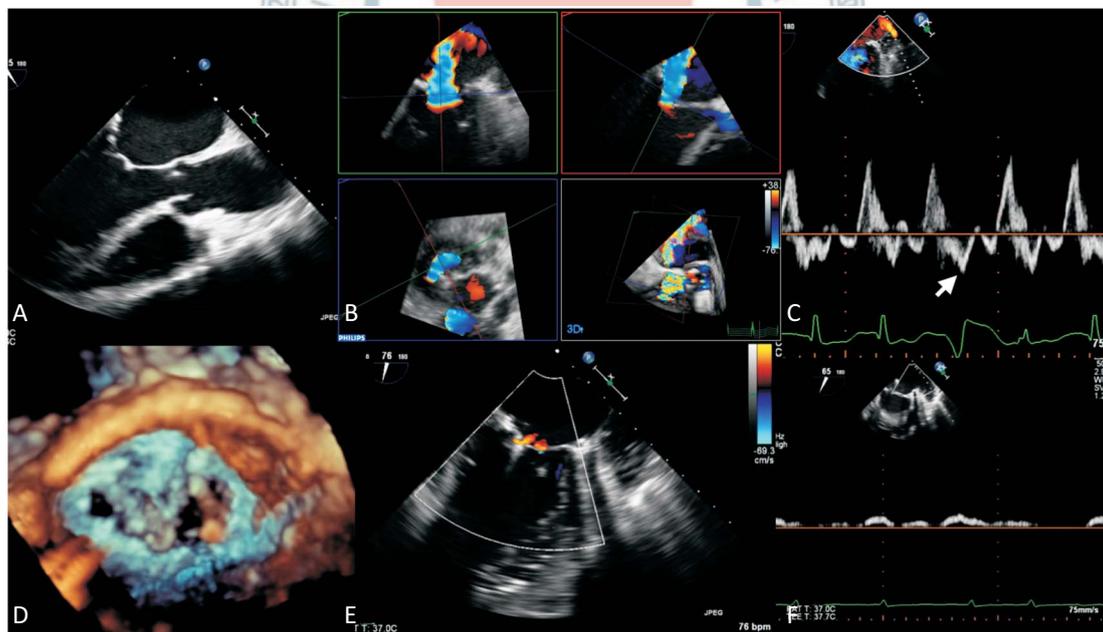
(A) TEE LVOT view demonstrated tethering of both mitral leaflets with a small gap between anterior and posterior leaflet. (B) QLAB 10.0 (Philips Healthcare) 3D color Doppler reconstruction demonstrated the significant MR jets coming from central A2-P2 site. (C) White arrow indicated the reversed systolic flow in left upper pulmonary vein. (D) 3D enface view from LV. It elucidated that the clip is located at central A2-P2 location. (E) TEE bi-commissure view with color Doppler demonstrated only mild MR left after a single clip. (F) TEE demonstrated disappearance of systolic reversed flow over left upper pulmonary vein. LV, left ventricular; LVOT, left ventricular outflow tract; MR, mitral regurgitation; TEE, transesophageal echocardiography.
